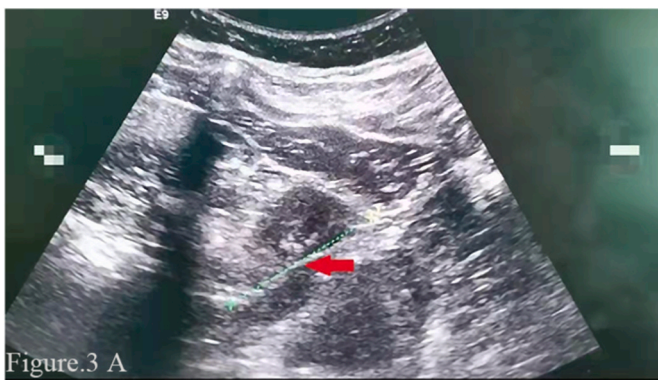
A: Intraoperative ultrasound monitoring: the foreign body is located in the duodenum-right lower renal pole (shown by the arrow). B: On the 4th day after operation, recheck the abdominal CT scanning image: dense shadow (hemostatic clips) can be seen in the descending segment of duodenum, showing changes after removal of foreign body.
